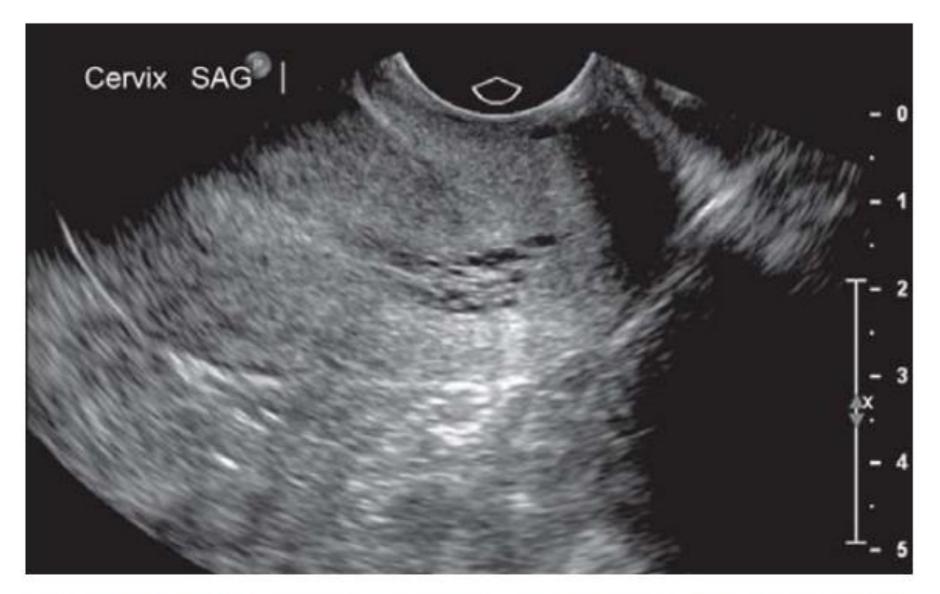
Shadowing artifacts on transvaginal ultrasound caused by air in the condom. Portion of the cervix and *cul-de-sac* are 'in the dark'
